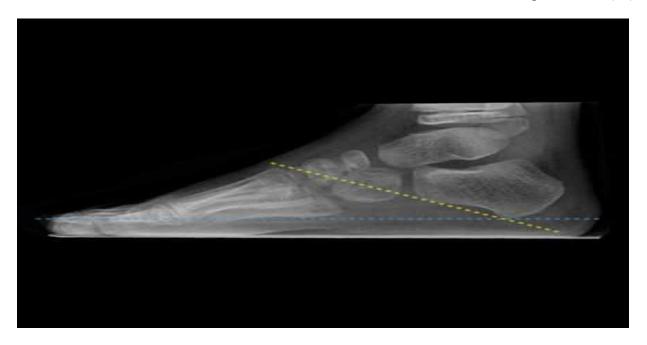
Calcaneal Inclination Angle on the Lateral Weight bearing Radiograph (18)
